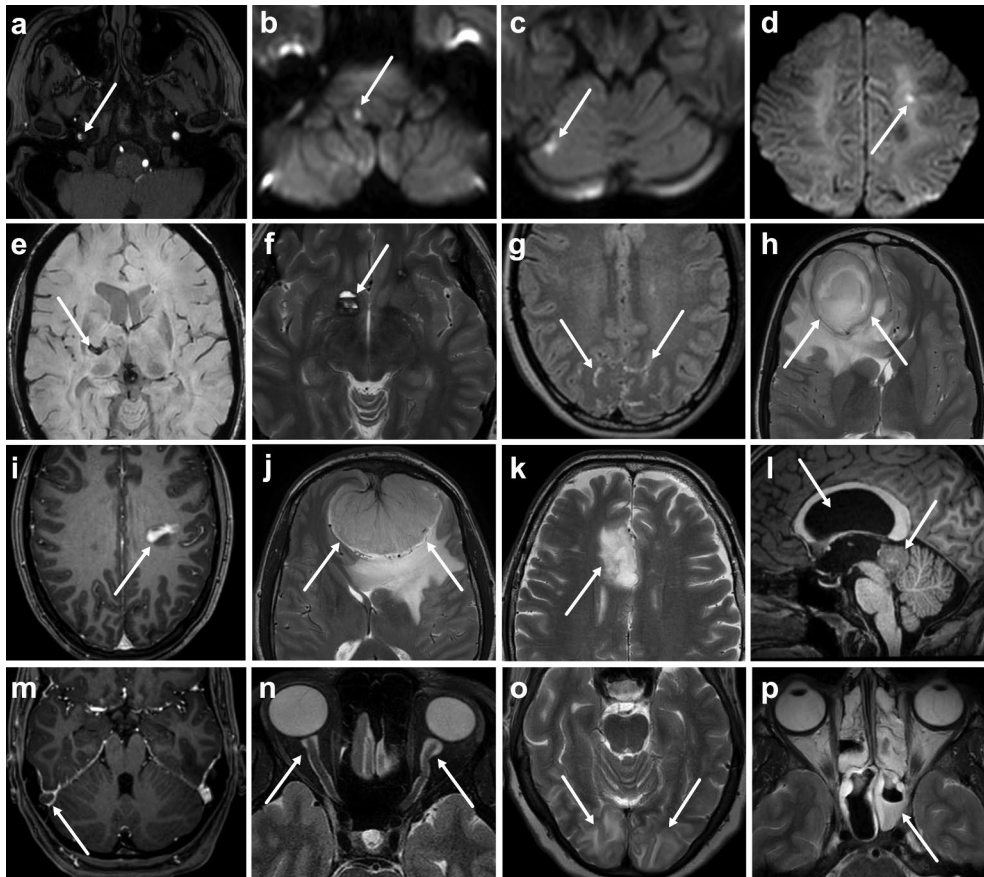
Examples of various emergency MRI findings of pathologies considered significantly related to headache. Examples are: internal carotid artery dissection (a), small infarcts (b–d), intracerebral hemorrhage (e), cavernoma (f), meningitis (g), abscess (h), demyelination (i), meningioma (j), glioma (k), central neurocytoma with hydrocephalus (l), dural venous sinus thrombosis (m), idiopathic intracranial hypertension (n), posterior reversible encephalopathy syndrome (o), and sphenoid sinusitis (p). White arrows denote relevant findings.
